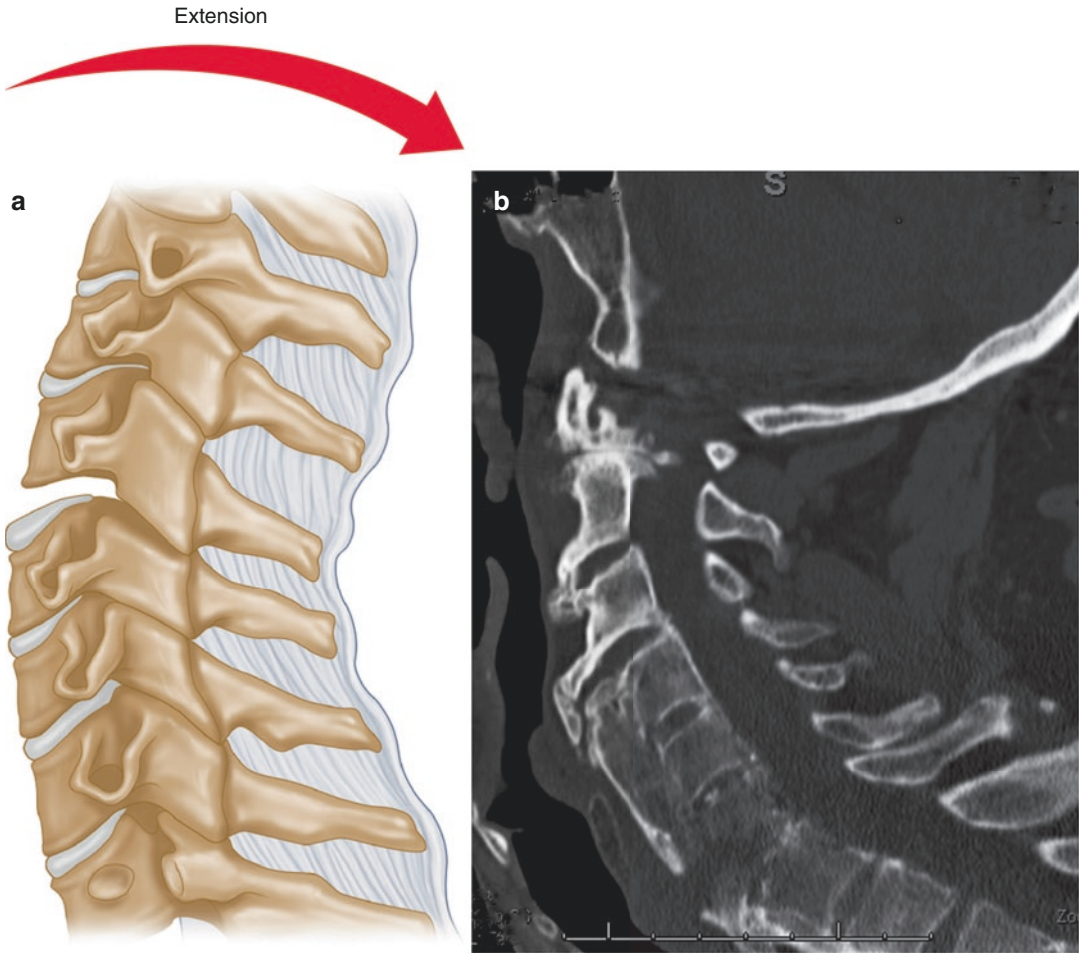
(a) An extension load leads to anterior tension injury and posterior compression. (b) Lateral CT image of extension injury of C-spine
